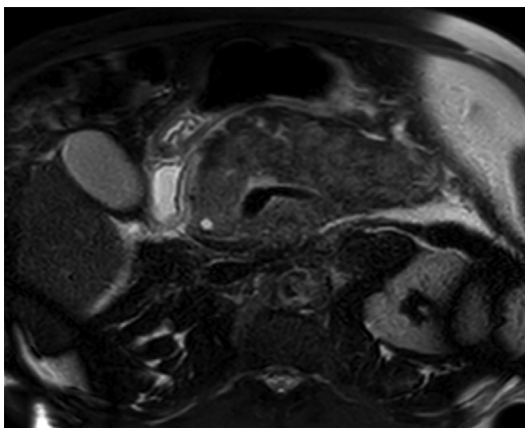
A 37-year-old man with hypertriglyceridemia and history of recurrent acute pancreatitis presents with epigastric pain of 2 days' duration and elevated lipase. Axial T2-weighted fat-saturated MR image of the abdomen demonstrates inflammation within the pancreatic parenchyma and peripancreatic soft tissues, consistent with interstitial edematous pancreatitis.
